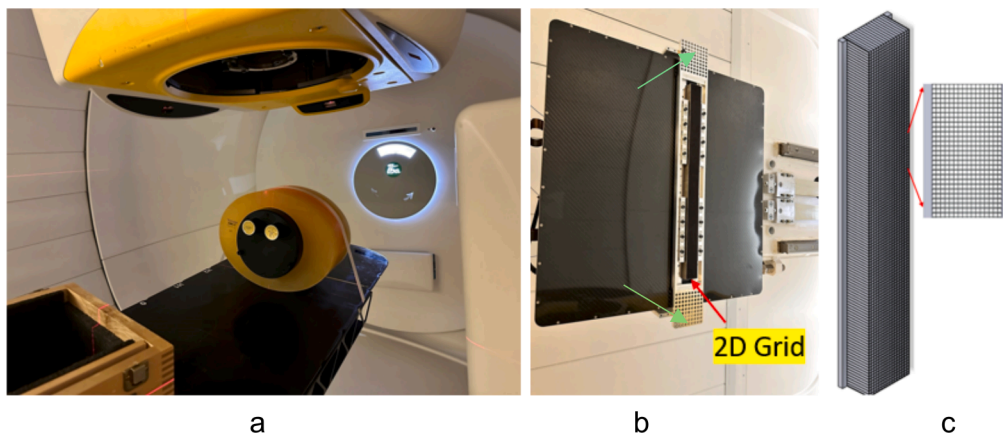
(a) CBCT imaging setup in the IBA Proteus Plus gantry. (b) The custom 2D-ASG mounting platform that was integrated with the FPD. (c) Sketch of the 2D-ASG prototype with mounting flanges on both sides.
